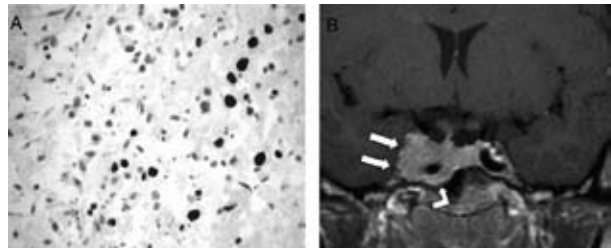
(A) High Ki-67 LI (11%) in a pituitary adenoma of a patient with acromegaly. (B) Pituitary MRI of the same patient performed after surgery demonstrates right cavernous sinus invasion.
